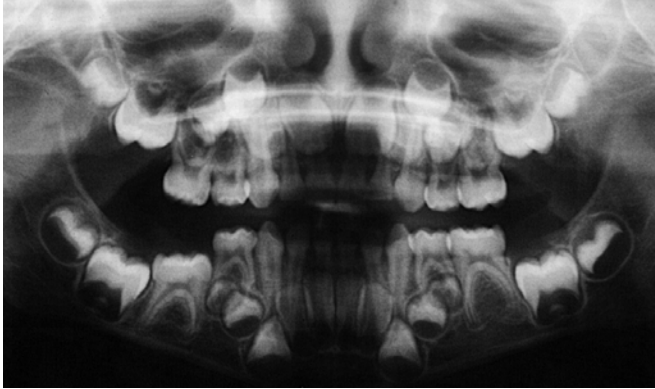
Panoramic radiograph of young boy with ectopic development of the second premolars in each quadrant. Instead of the second premolar crypts forming in the bifurcation of the primary second molar's roots, as is normal, they are ectopically malpositioned apical to the primary first molars. Malpositions of the succedaneous tooth crypts is one possible cause of the maloccluded premolars seen in cases 1 and 2, though here—with all four quadrants involved—the problem probably is systemic rather than local.
